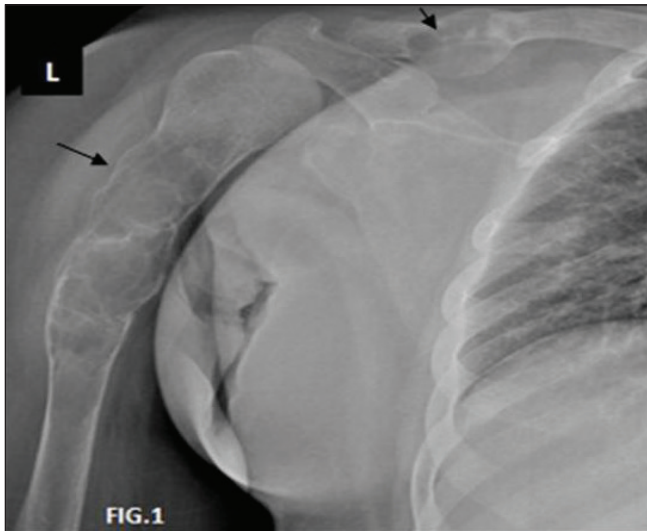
X-ray left shoulder joint showing, expansile, radiolucent lesion involving meta-diaphyseal region of left humeral shaft and another similar lesion involving lateral third of left clavicle.
